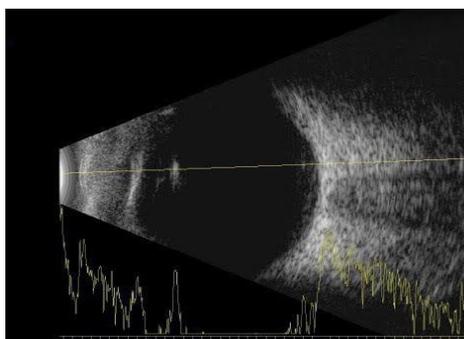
B-Ultrasound intraocular FB
